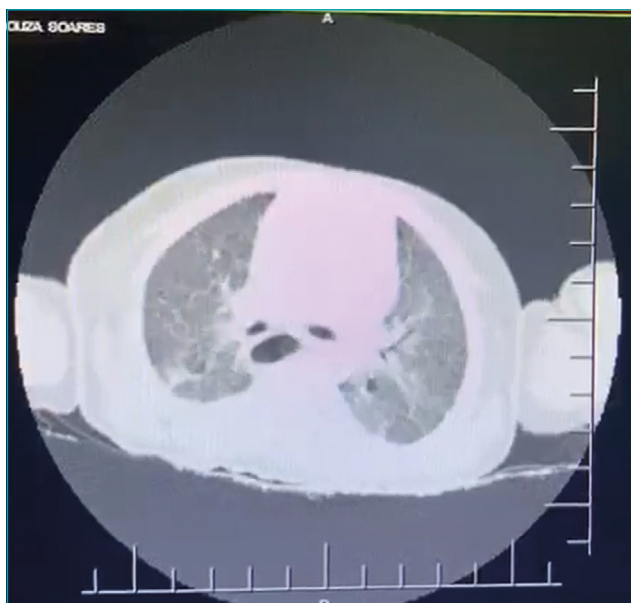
Axial images of the thoracic computed tomography, performed in the beginning of the hospitalization period, caused by the coronavirus disease 2019, showing bilateral ground-glass opacities in the mid and lower segments.
